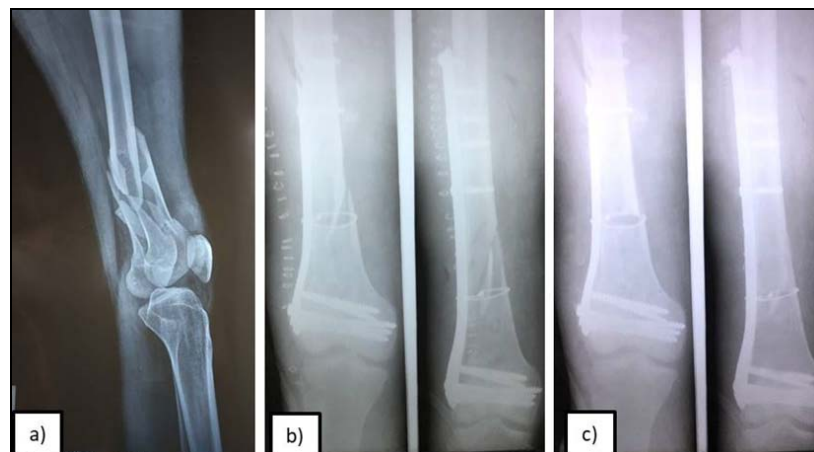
Radiograph a) Preoperative, b) Immediate Postoperative, c) Postoperative 6 months
